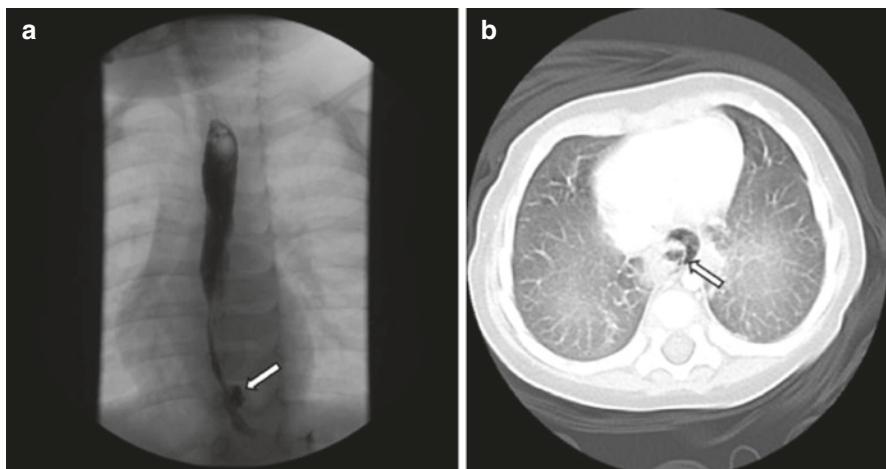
(a) Water-soluble contrast esophagram demonstrating a mid-esophageal perforation (arrow) with extravasation of contrast material into the mediastinum and no extravasation into the pleural space [8]. (b) Computed tomography of the chest demonstrating the esophageal wall with perforation (arrow) in the axial view. There is no contrast that was administered. There is no contamination of the pleural space [8]
